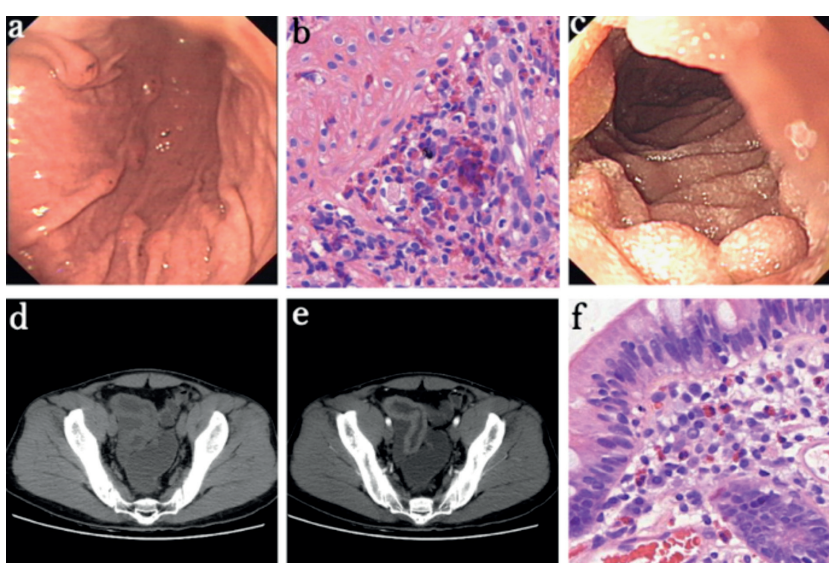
(a-f). A patients with eosinophilic gastroenteritis : (a) endoscopic view of small protruding lesions patchily distributed in the stomach ; (b) Massive infiltration of eosinophils in the gastric mucosa ; (c) Enteroscopic view of small protruding lesions found in the small intestine ; (d) Computed tomography (CT) showed a segment of the distal ileum was diffused thickness ; (e) Contrast-enhanced CT showed the segment of the distal ileum had homogeneous density ; (f) Massive infiltration of eosinophils in the intestinal mucosa.
